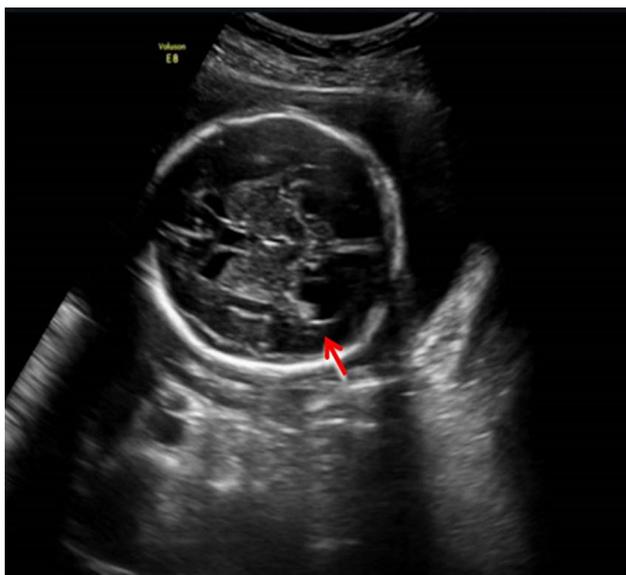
Ultrasound examination showing left ventriculomegaly (11.1 mm).
